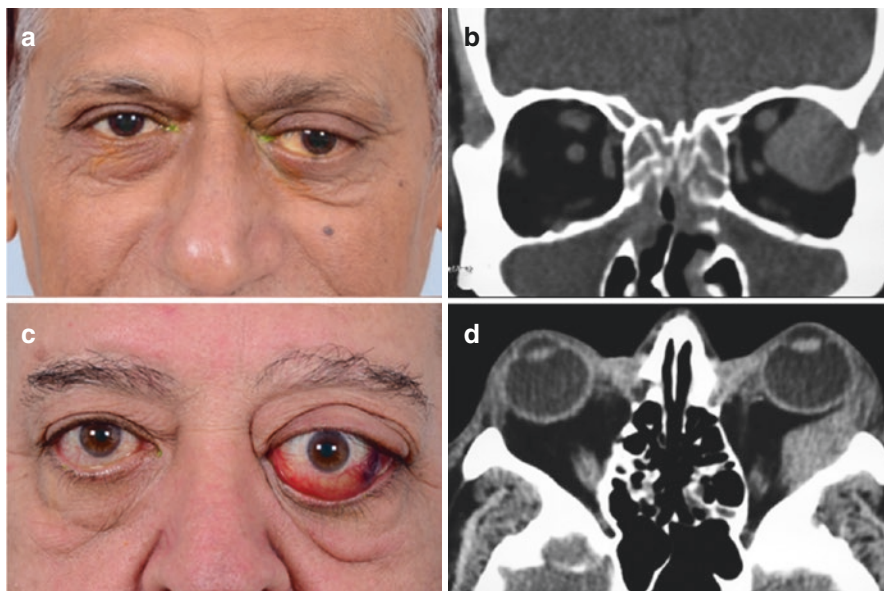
Orbital lymphoma. (a) A 59-year-old male with left proptosis. (b) Coronal CT orbit reveals a left supertemporal orbital mass in the lacrimal fossa, with bony indentation and no bone destruction. (c) A 60-year-old male with left proptosis and conjunctival injection. (d) Axial CT orbit shows a mass lesion along the lateral rectus muscle extending upto the mid-orbit
